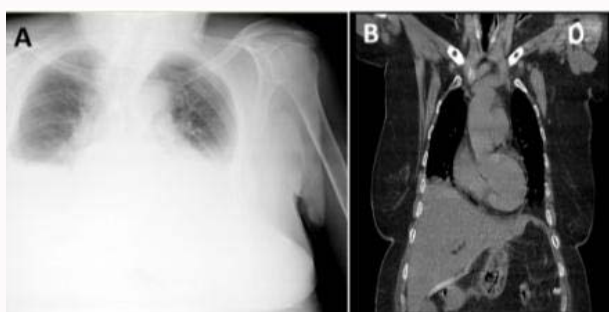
Postoperative images: A) Chest X-ray, B) Sagittal image of thoracic-abdominal computerized tomography.
